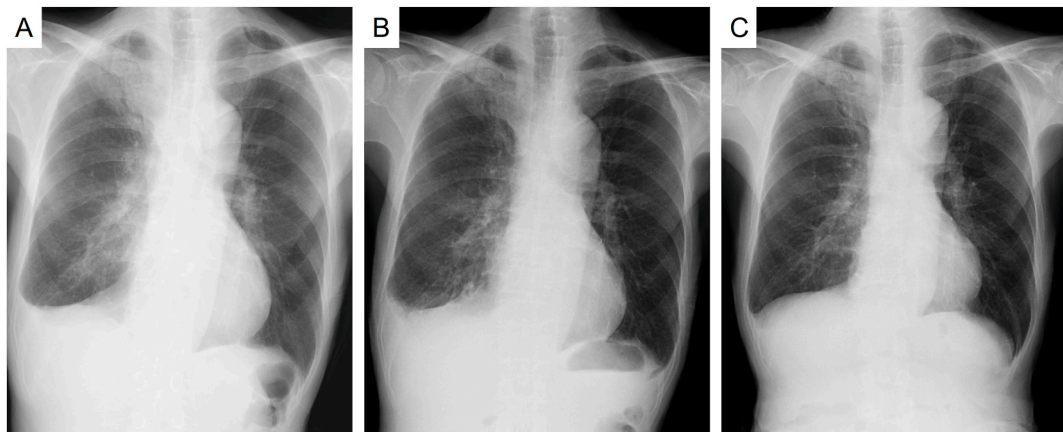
Follow-up chest X-ray before and after the treatment. Day 0 corresponds to the initiation of oral prednisolone (PSL), and PSL was stopped on day 88. On day 15, the X-ray (when he visited his primary care doctor) showed right pleural effusion and osteosclerosis of the right sternoclavicular joint. On day 6 (when he was discharged), a similar amount of pleural effusion was detected, but the osteosclerosis was reduced (B). The right pleural effusion was gradually reduced, and almost no pleural effusion was observed on day 96 (C). The shadow of the right sternoclavicular joint persisted.
